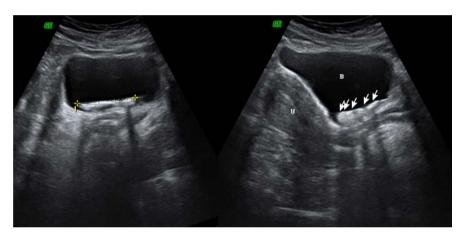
Axial and sagittal trans abdominal ultrasound images shows dense intra bladder stone like lesion with metallic artifact (arrows), (U) uterus, (B) bladder.
